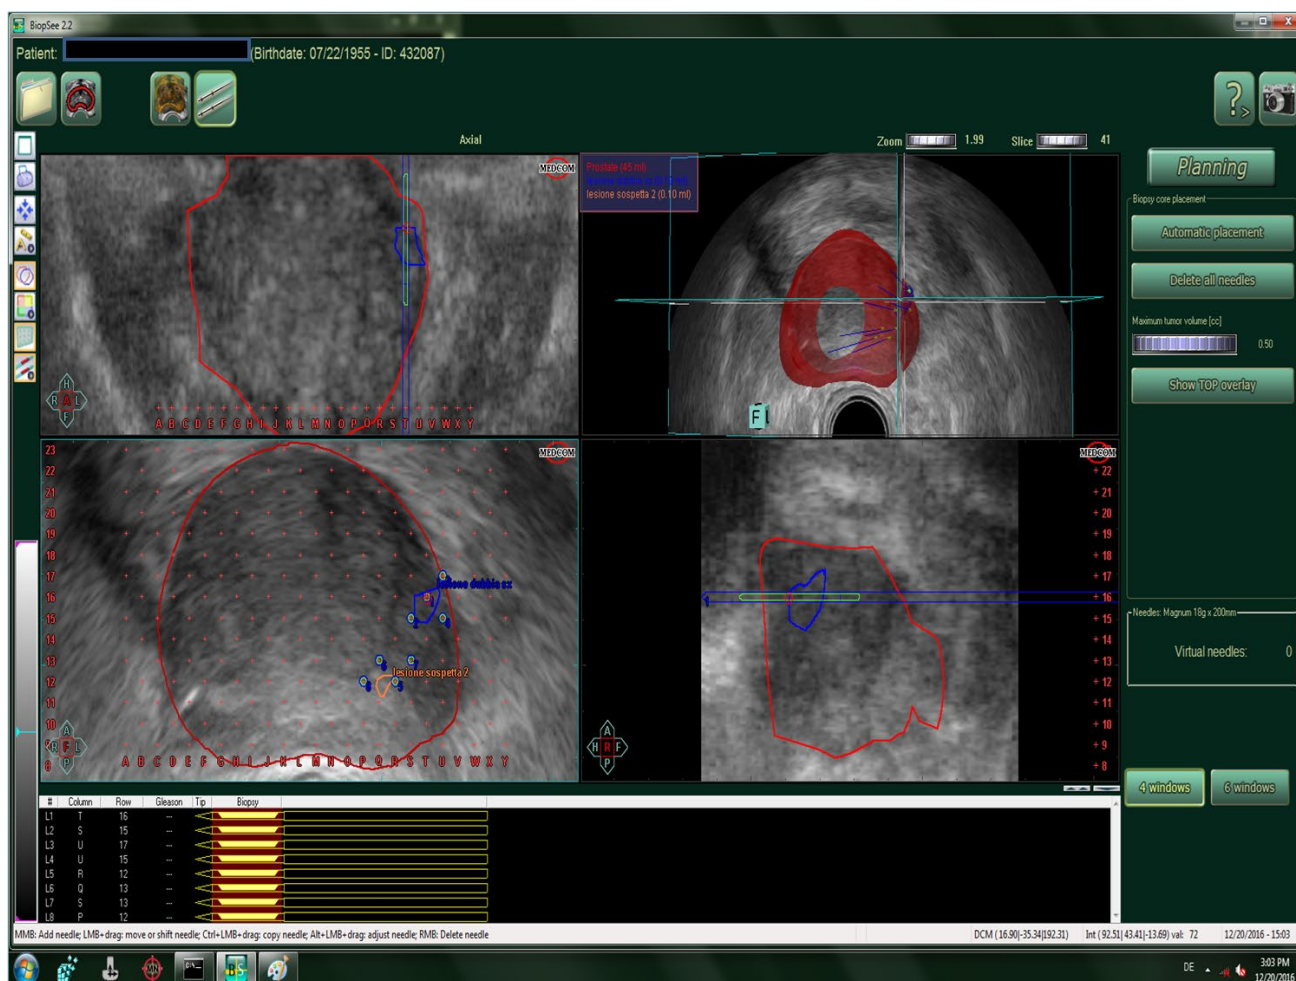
Tridimensional and computerized transperineal prostate MRI/TRUS fusion biopsy “Biopsee® system”: coronal plane (top left); axial plane plus targeted cores (top right, bottom left), longitudinal plane with targeted core into suspicious area (bottom left)
